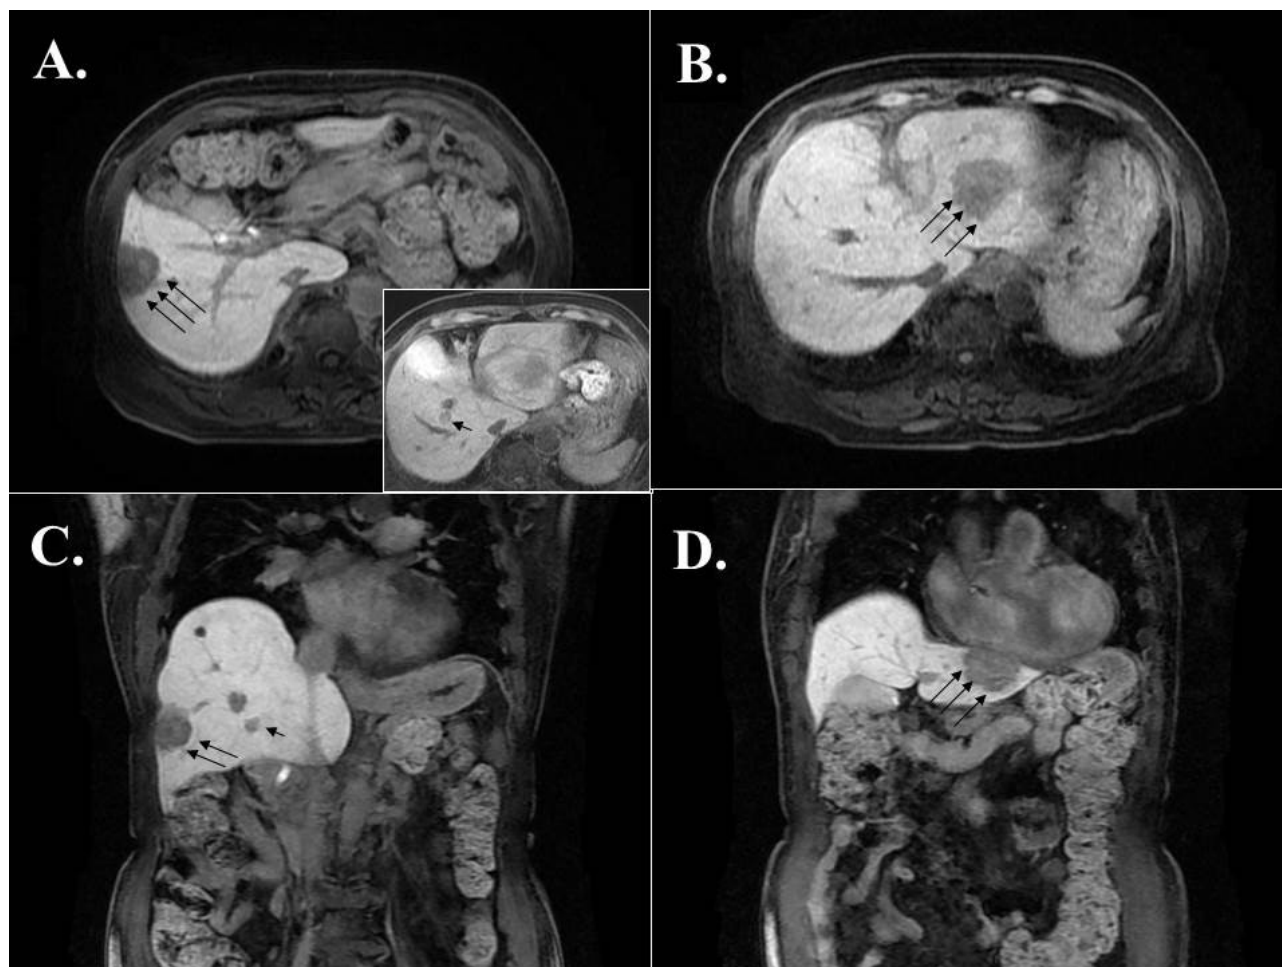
Magnetic resonance images demonstrated multiple bilobar liver masses indicating multiple liver metastases from colon cancer. (A, C) A 3.5cm-sized mass in S6 (long arrows) and a 1.5cm-sized mass in S5 (a short arrow) were shown. (B, D) A large 4.5cm-sized mass in the left lobe was shown (arrows). A,B: axial images, C,D: coronal images.
